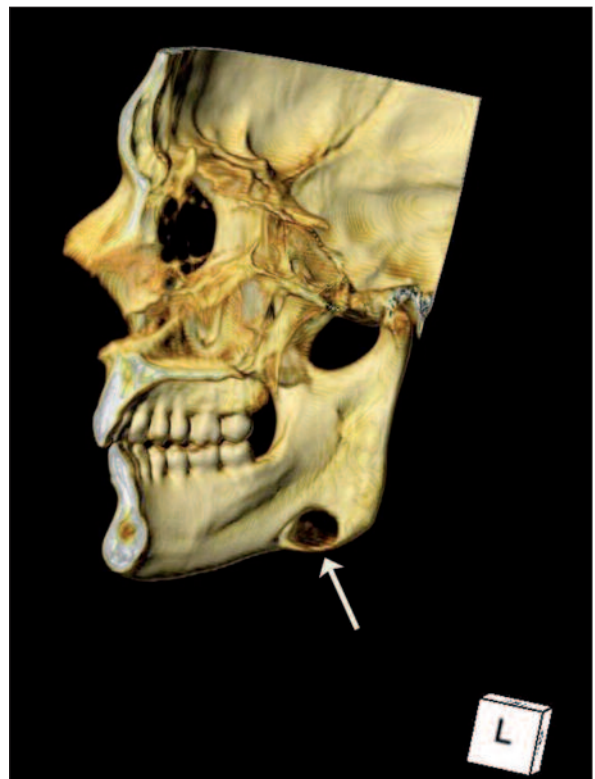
Three-dimensional reconstruction of a CT. The bone depression (Stafne's cavity) can be seen in the lingual area of the mandible.
